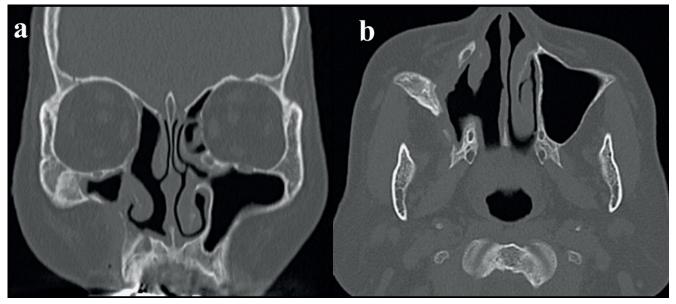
Postoperative follow-up computed tomography images of paranasal sinuses at 6 months confirm the absence of postoperative recurrence. Coronal (a) and axial (b) sections of the paranasal sinuses show air in the right maxillary sinus and preserved pyriform aperture, respectively.
